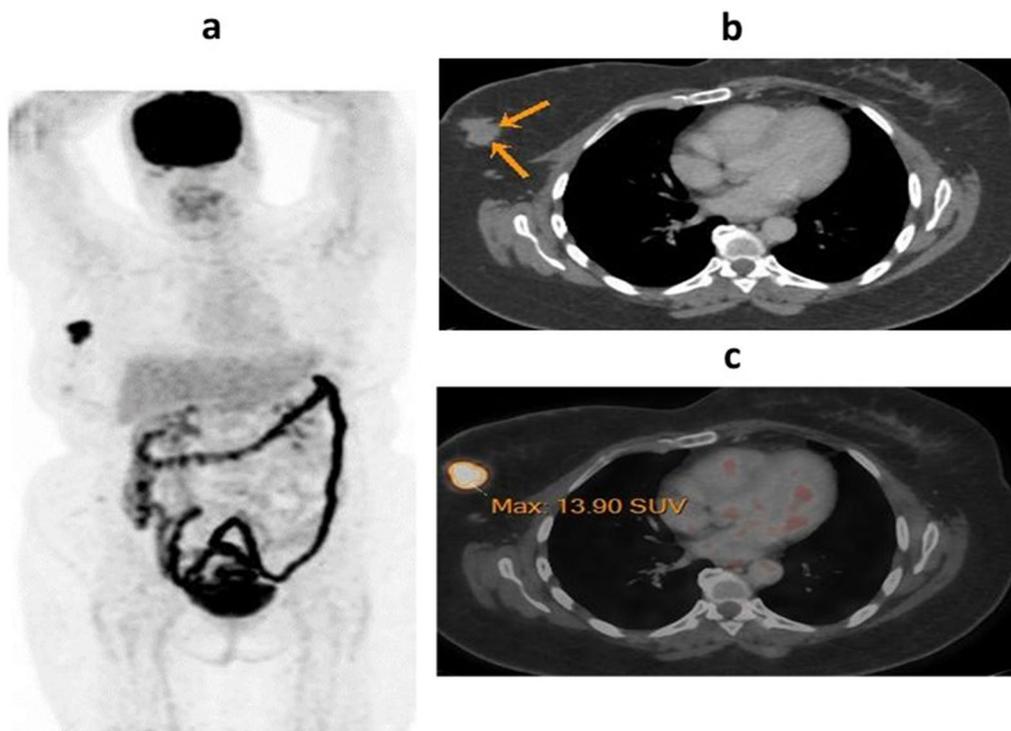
A 55-year-old female patient arrived with newly diagnosed right breast cancer (adenoid cystic carcinoma). a A whole-body PET MIP picture indicated an active right breast lesion with no additional hypermetabolic lesions found anywhere else on the body. b, c Axial CECT and fused PET/CT images revealed speculated hypermetabolic soft tissue lesion at upper outer quadrant of the right breast, measuring about 23 × 27 mm and achieving up to 13.9 SUVmax
